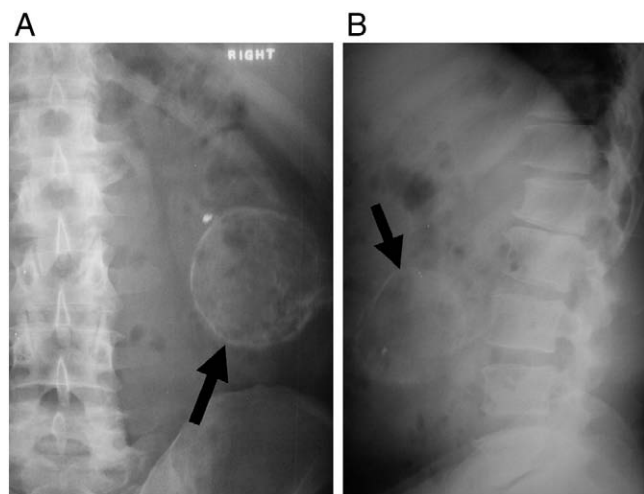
Anterior-to-posterior (A) and lateral (B) recumbent radiographs show a large calcified mass (arrows) in the region of the right kidney. Degenerative changes are noted in the spine.
